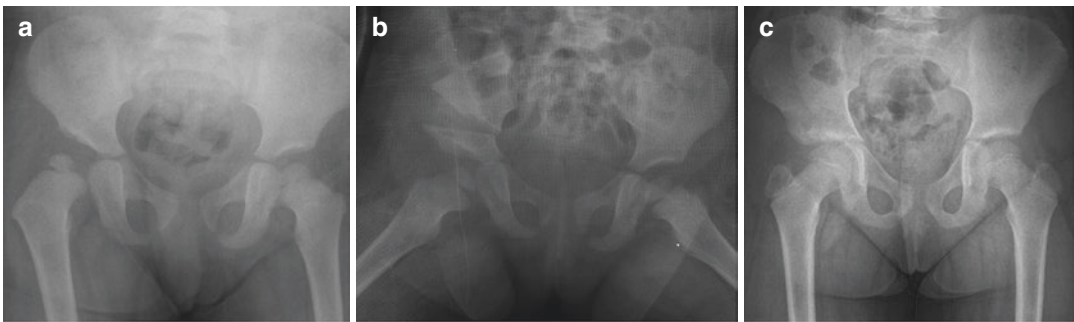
(a) AP X-ray of a 22-month-old girl showing the incidentally diagnosed dysplasia of the right hip. (b) Initial postoperative AP X-ray showing perfect anterolateral coverage of the hip after a modified Salter osteotomy
